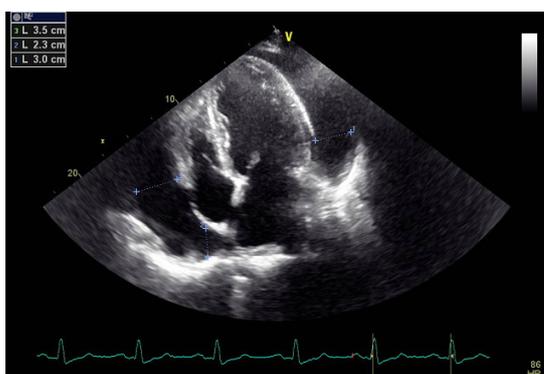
Apical view in transthoracic echocardiography showing the circumferential pericardial effusion with no tamponade sign.
